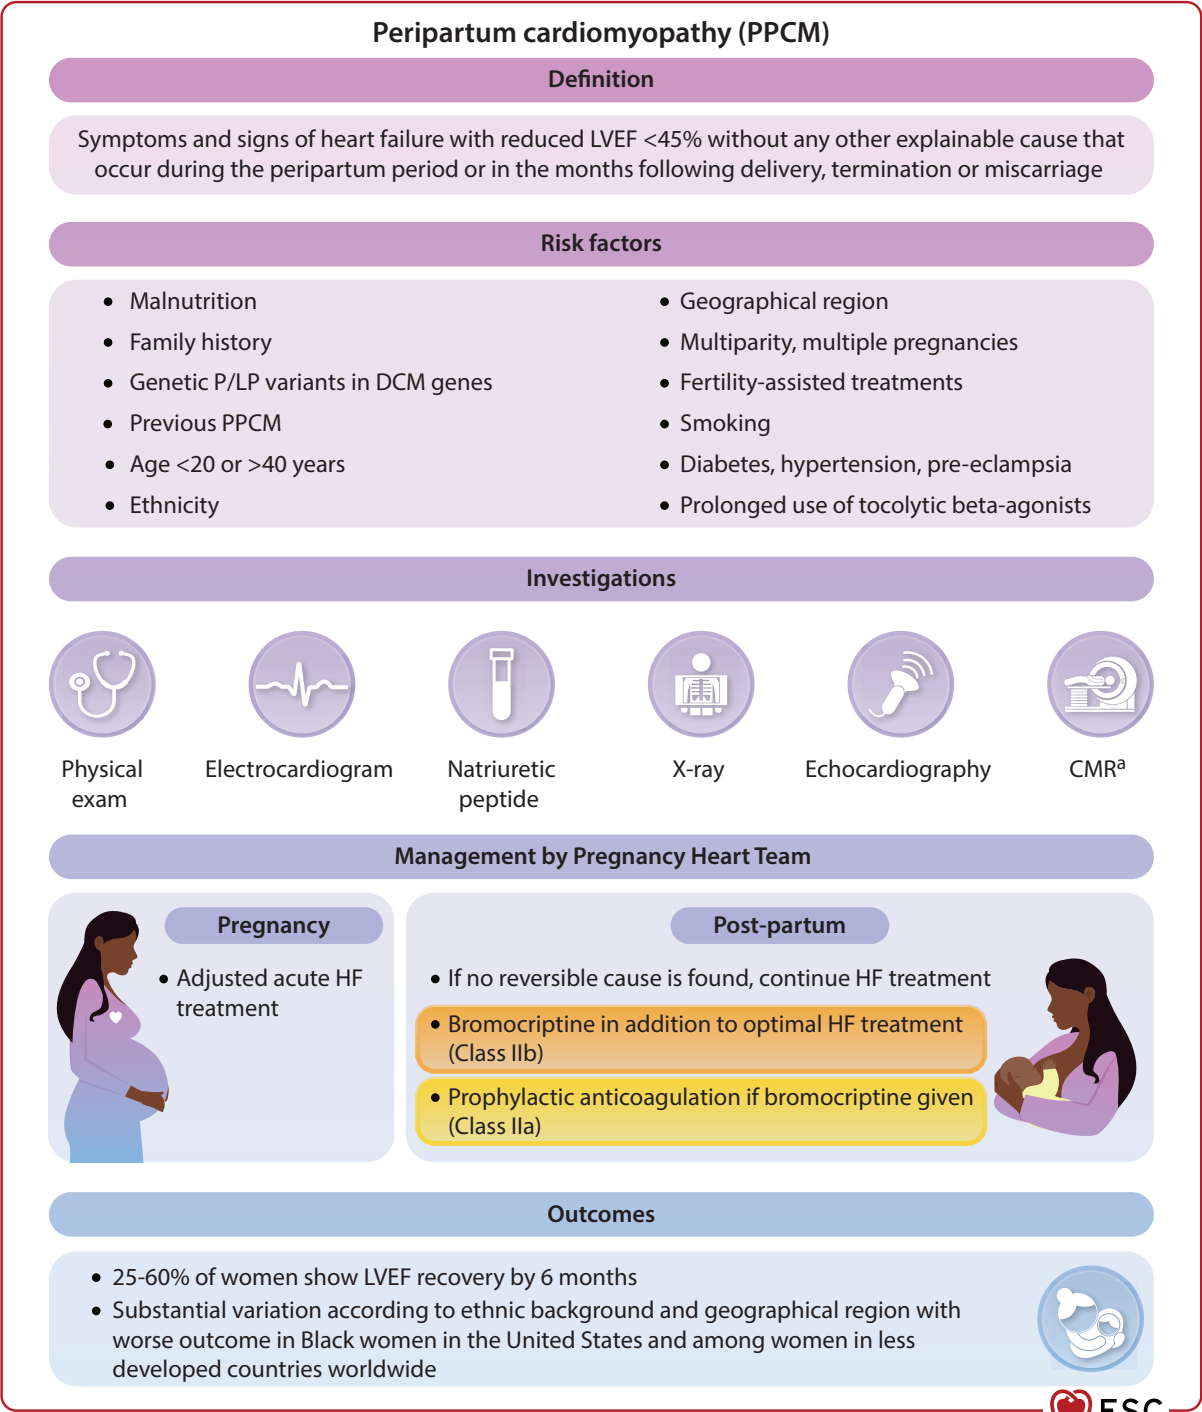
Risk factors and management of peripartum cardiomyopathy. CMR, cardiac magnetic resonance imaging; HF, heart failure; LVEF, left ventricular ejection fraction; P/LP, pathogenic/likely pathogenic; PPCM, peripartum cardiomyopathy. ^aIn specific cases.
